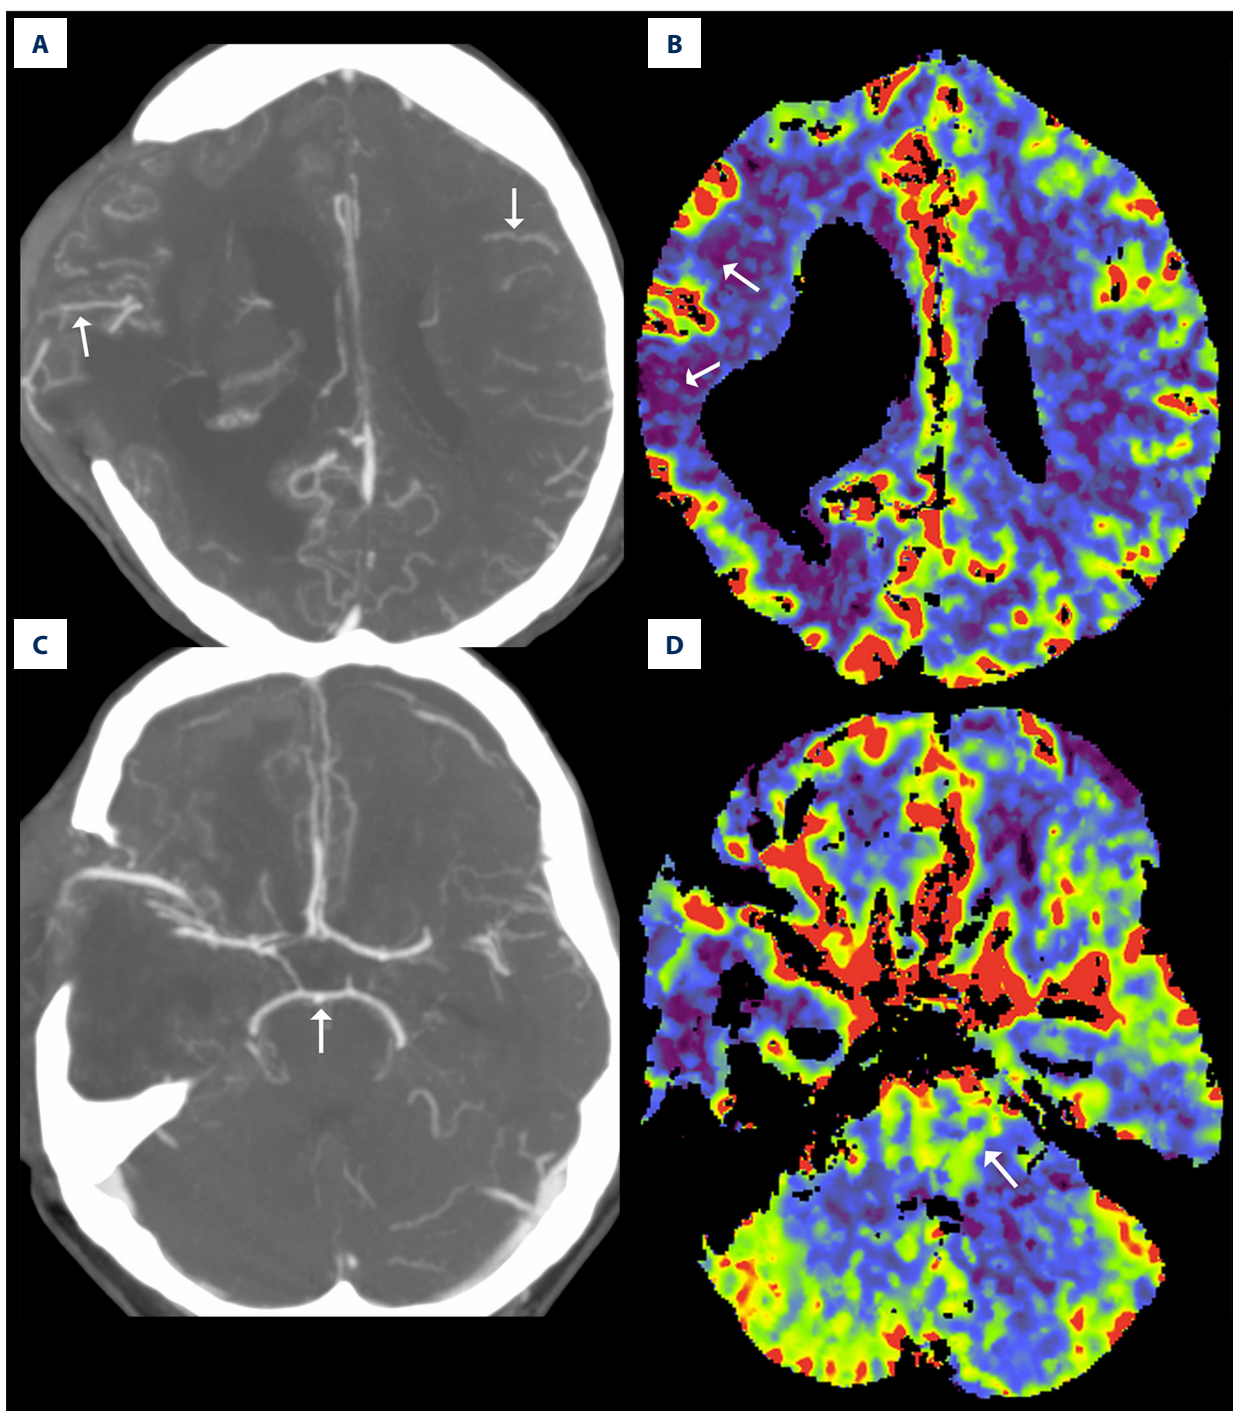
Results of CTA (A, C) and CTP (B, D) in the patient with devastating brain injury following cardiac arrest, in coma on artificial ventilation, but with preserved brainstem reflexes. CTA shows preserved bilateral filling of cortical branches of the MCAs (arrows in A) and the basilar artery (arrow in C); this result was interpreted as negative (i.e., inconsistent with the diagnosis of BD). CTP reveals decreased CBF in the right fronto-parietal region (arrows in B) with preserved cerebral perfusion in all other regions, including the brainstem (arrow in D). This result was interpreted as negative (i.e., not consistent with the diagnosis of BD).
